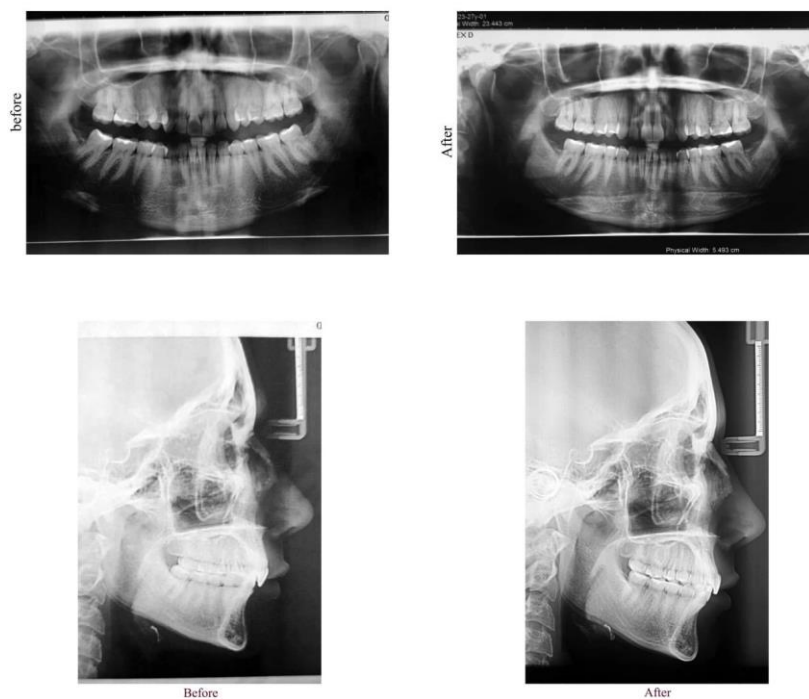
(Case IV): Before and after treatment radiography in a 24 years old girl
